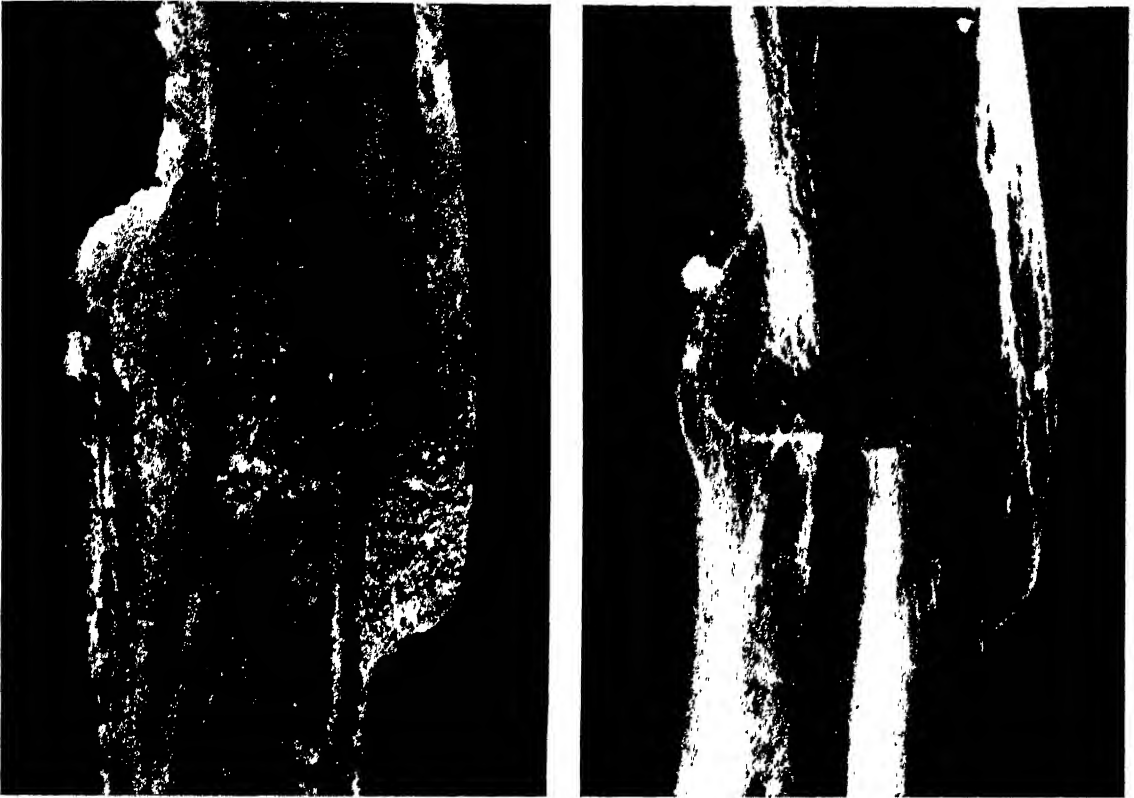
This fracture through the midshaft of the femur united with anterior shift of the proximal fragment. Eighteen months after fracture there is firm bony union. The slab radiograph shows how the provisional callus has become remodelled along lines of stress with buttressing of the posterior and slightly concave part of the fracture line and some retubulation in the medullary canal at the fracture site.
